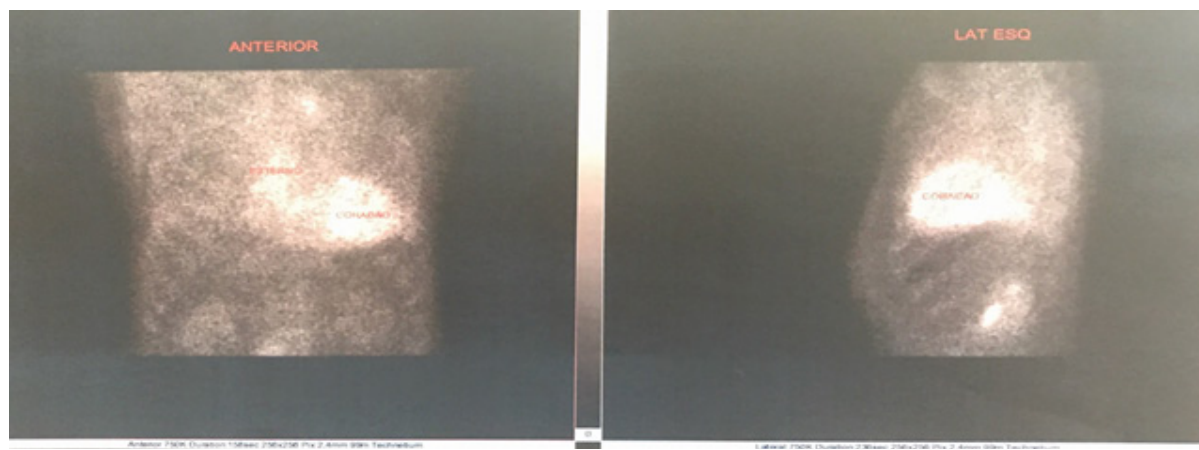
Myocardial scintigraphy with technetium-99m labelled pyrophosphate. 2.1) Counting ratio between the heart and the corresponding site in the right hemithorax = 1.8 (31/17 = 1.8). 2.2) Increased concentration of the radiotracer in the projection area of the heart against the costal margin, corresponding to score 3. Score >2 and counting ratio between the heart and the contralateral region >1.5 have a high probability of senile or hereditary transthyretin amyloidosis.
